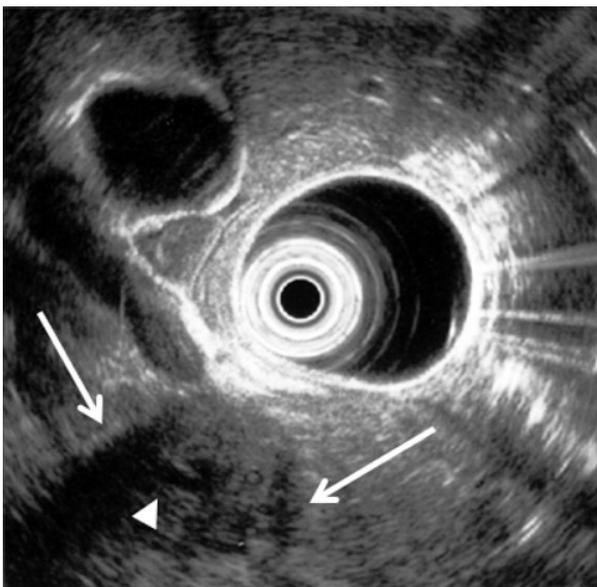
Endoscopic ultrasonography showing a low echoic mass (arrows) with penetrating duct sign (arrow head) 30 mm in diameter in the pancreatic head.
